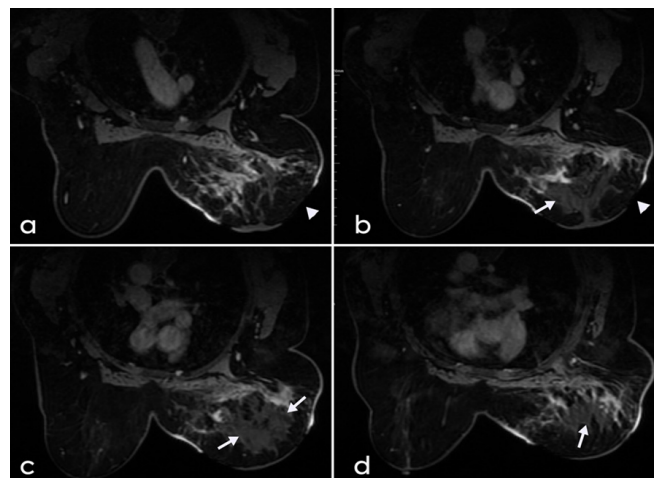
Contrast-enhanced MRI revealed skin necrosis (arrow heads) (a-b) in the right breast and hypovascular area (arrows), suggesting necrosis in the retroareolar area (b-c-d).
